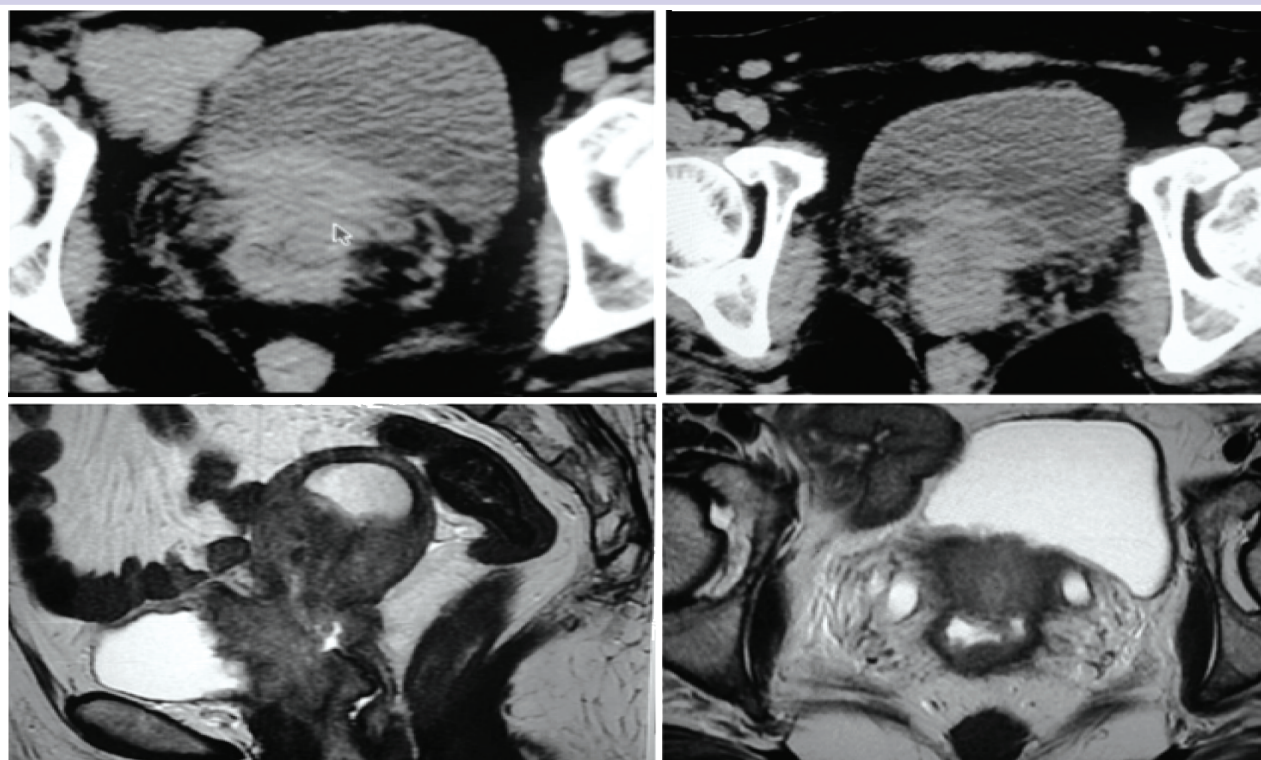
Cervix-CT and MRI showing carcinoma infiltrating bladder, vagina and uterus (stage IVA).
